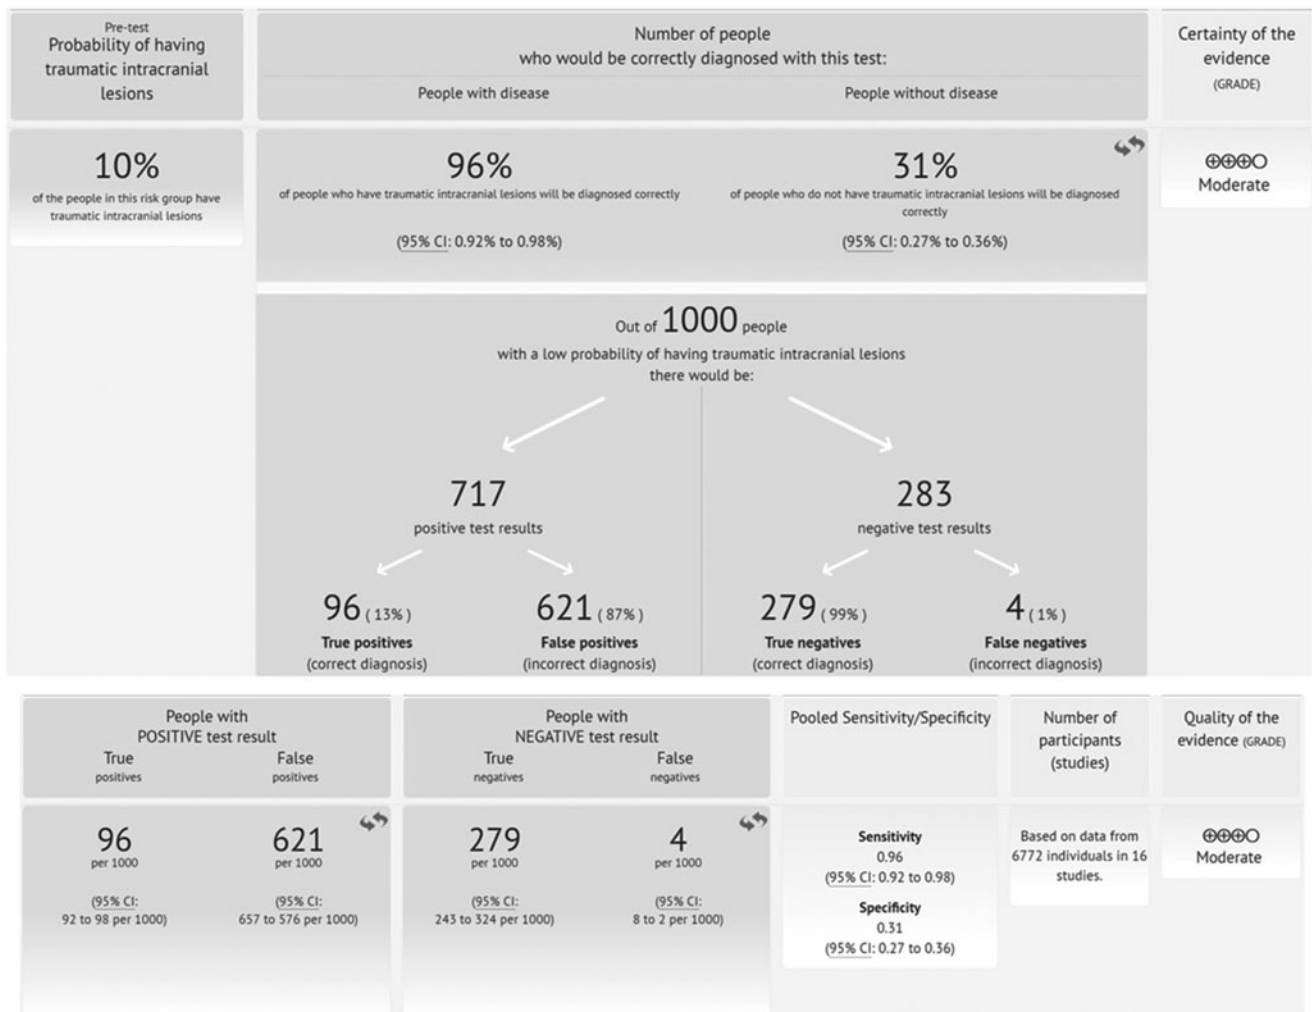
Summary of evidence for the use of blood S100 calcium binding protein B (S100B) protein concentrations (0.10–0.11 µg/L cutoff) to diagnose brain injury as assessed by CT scan in patients with mild traumatic brain injury (mTBI).
